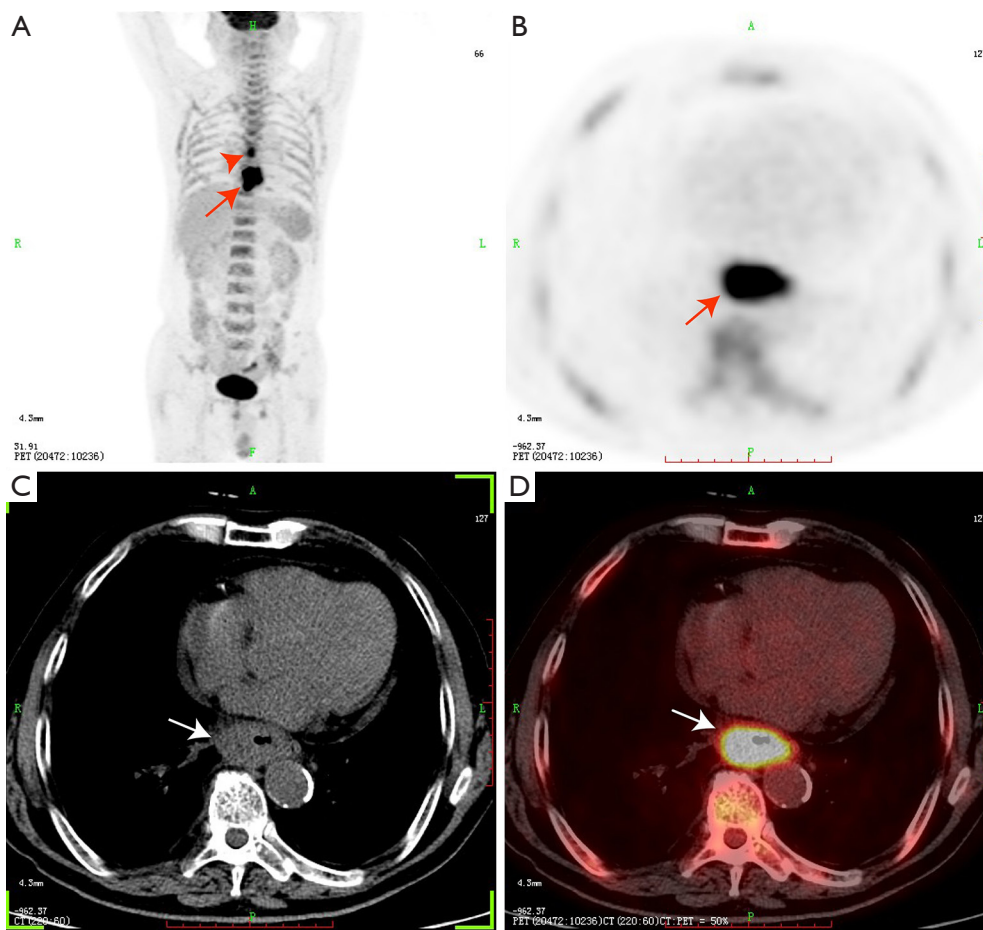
Thickening of the esophageal duct wall. Abnormal ^{18}F -FDG uptake in the esophageal lesion and the metastatic lymph node in the mediastinum. (A,B) The maximum density projection and axial PET image. (C,D) The axial CT and PET/CT image. PET and PET/CT images showed increased ^{18}F -FDG uptake in esophageal lesion (arrows in A, B and D). The mediastinal metastatic lymph node increased ^{18}F -FDG uptake (A, red arrowhead). In addition, axial CT of the mediastinal window showed uneven thickening of the esophageal wall (C, arrow). PET, positron emission tomography; CT, computed tomography; ^{18}F -FDG; ^{18}F -fluorodeoxyglucose.
